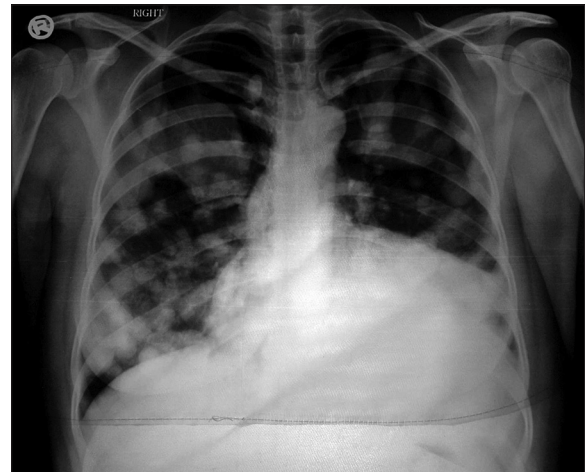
Chest radiograph showing bilateral multiple cotton fluffy balls suggestive of metastasis
